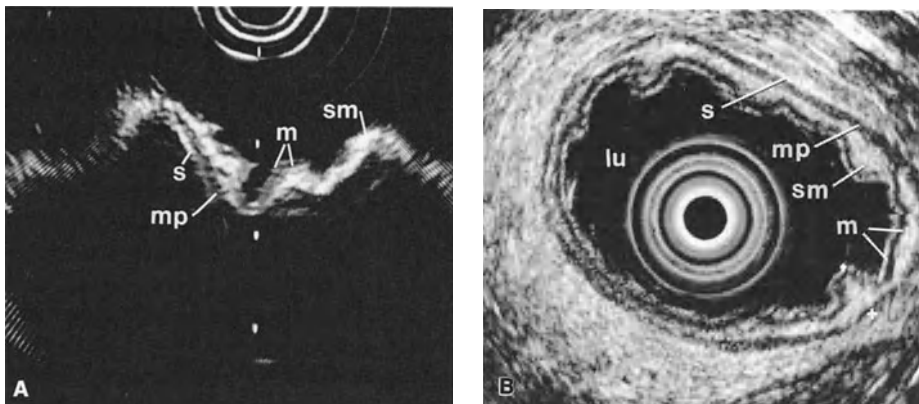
A, B. Endoscopic sonograms. A Five-layer structure of intestinal wall. Note the clear transition between the intact wall and the area where the various layers were partially removed. The dark line (*mp*) and the white line (*s*) disappear in the area where they were removed. B Normal gastric wall seen as a five-layer structure after the lumen (*lu*) had been adequately filled with water. *m*, mucosa; *sm*, submucosa; *mp*, muscularis propria; *s*, subserosa and serosa
